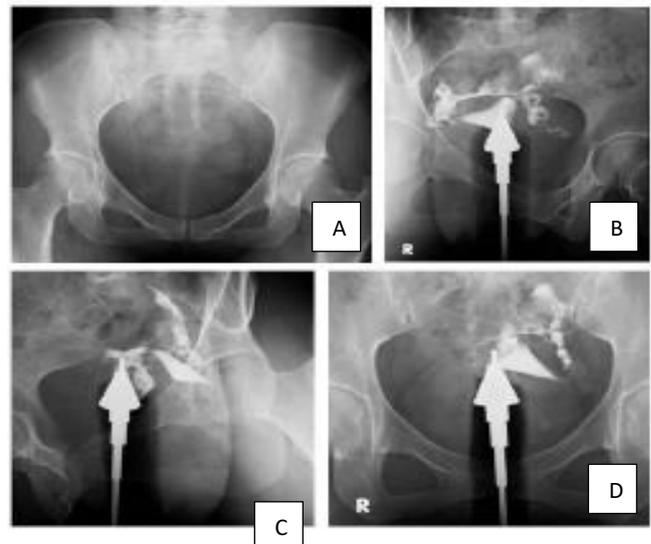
Salpingitis (A): Plain radiograph. (B), (C), (D): Contrast fills the uterine cavity and both fallopian tubes. The cervical canal appears normal with smooth edges. The uterine cavity is anteflexed, with normal size and shape, smooth mucosa, and no filling defects or additional shadows. Peritubal filling is observed in the left fallopian tube at the isthmic portion, with dilation in the ampullary part. The surrounding mucosa appears regular, and peritoneal spillage is present (+). Contrast fills the right fallopian tube with peritoneal spillage (+).
